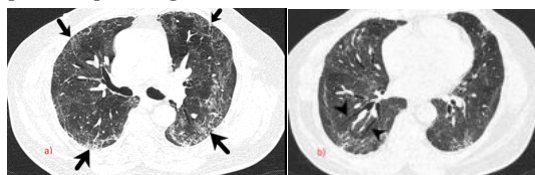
Axial nonenhanced CT lung window section in 71 year old male in late recovering stage of COVID-19 showing a) Subpleural interstitial septal thickening, fibrosis, Subpleural atelectasis (arrow) and b) tractional bronchiectasis (arrowhead).
